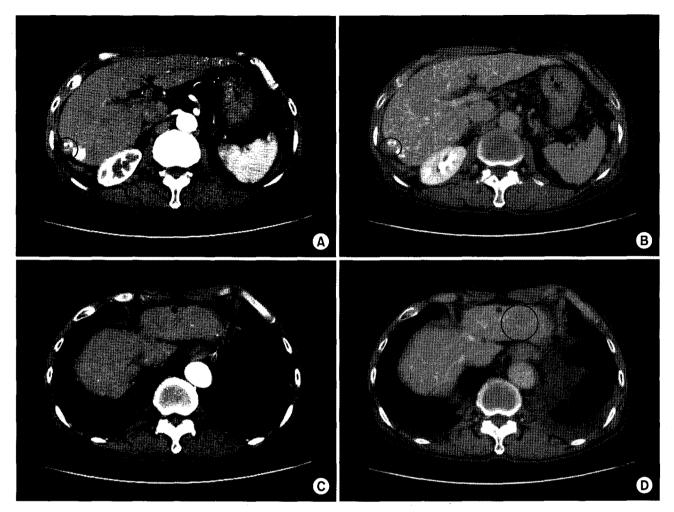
Abdominal CT scan of 72 year-old male hepatocelluar carcinoma (HCC) patient (case 2) before hepatic irradiation. (A) There was lipiodolized nodule with viable tumor in segment 6. On arterial phase, the nodule was enhanced (black circle). (B) There was lipiodolized nodule with viable tumor in segment 6. On delayed phase, the nodule washed out (black circle). (C) There was probable HCC-like mass in segment 2. On arterial phase, the mass was not enhanced. (D) There was probable HCC-like mass in segment 2. On delayed phase, the mass washed out (black circle).
